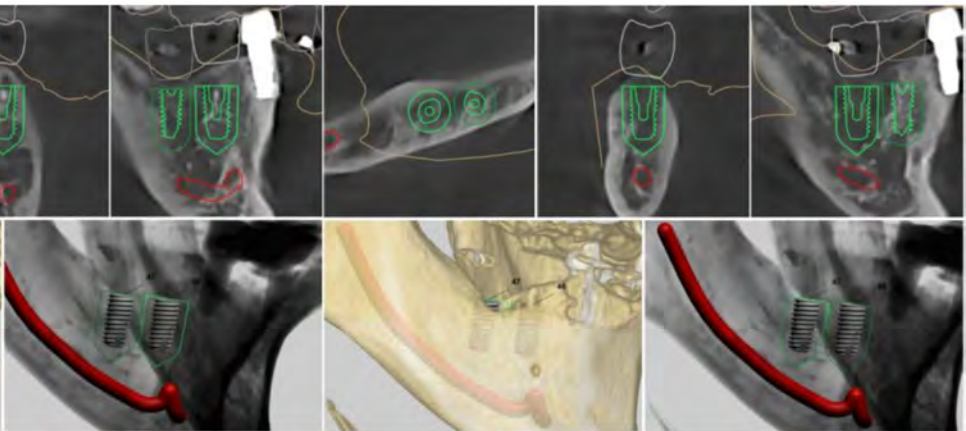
CT image for implant placement planning.
